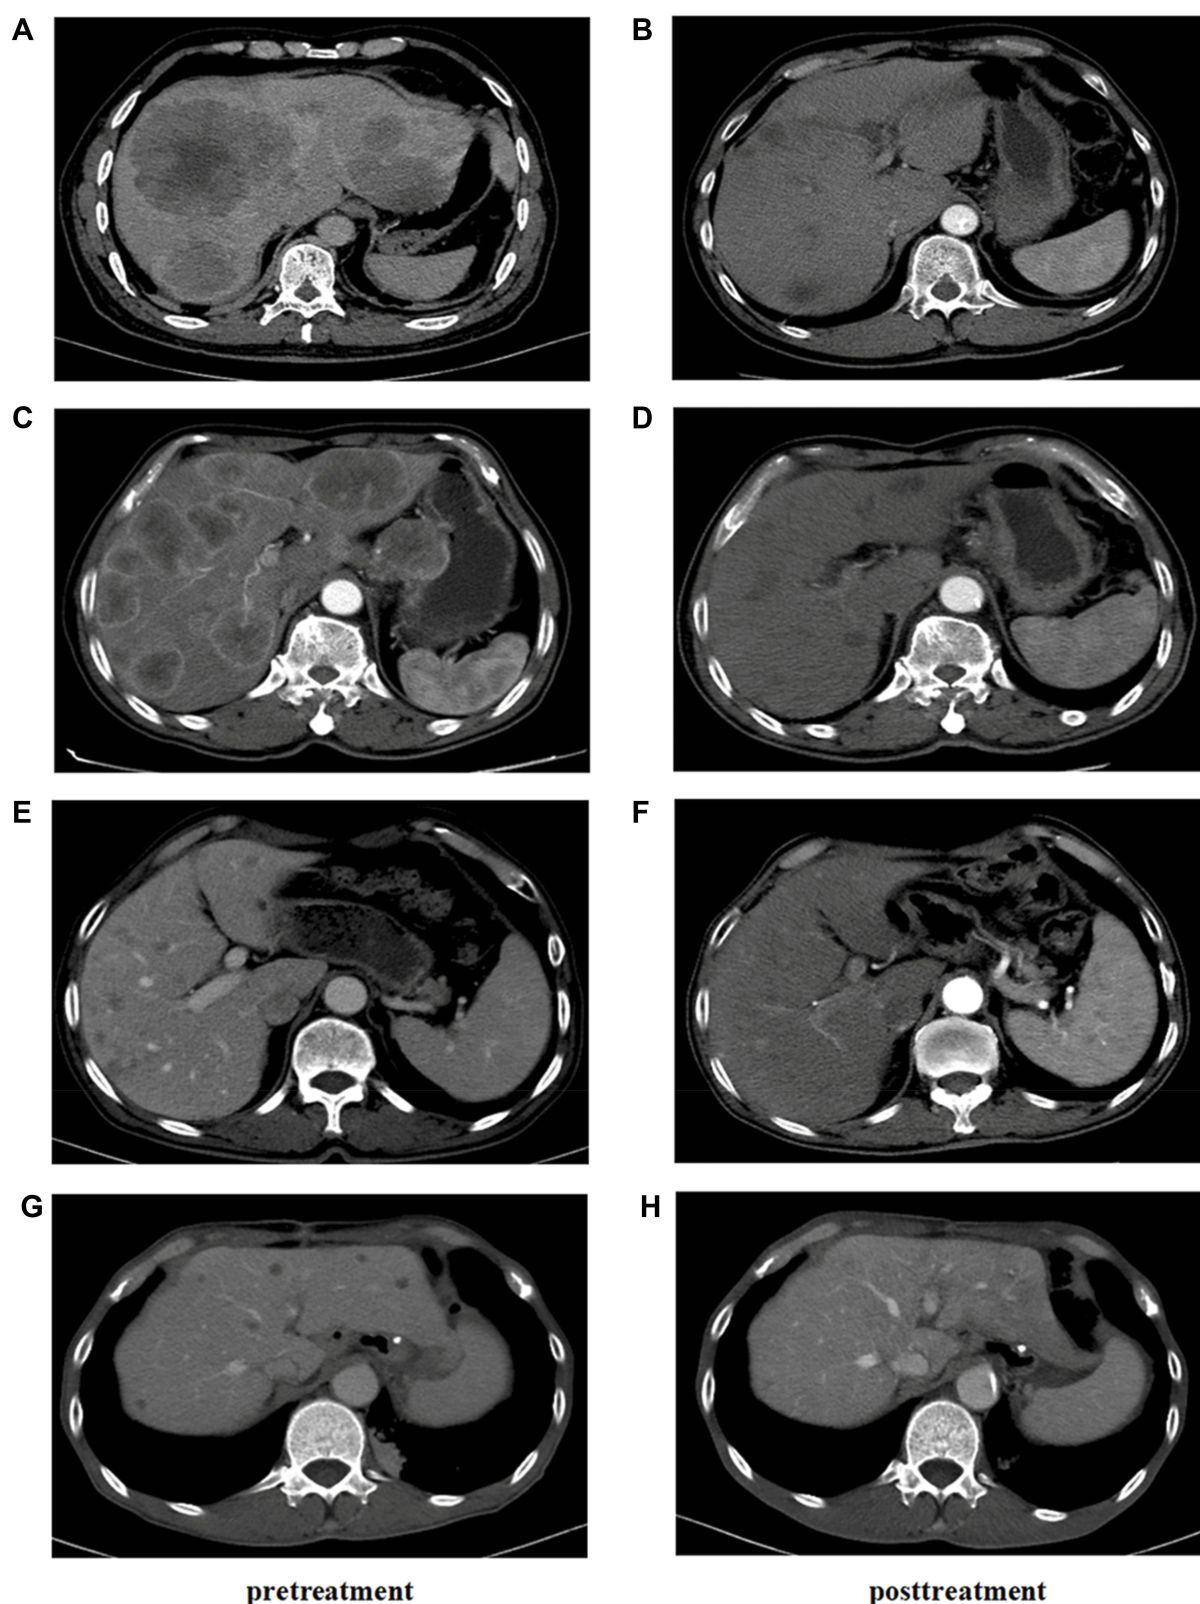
Follow-up CT scans after two cycles of HAI and systemic chemotherapy for each patient except No. 3 whose data were unavailable. (A, B) Patient No. 1, 58-year-old male showing marked liver metastases in CT images before therapy (A) and a significant shrinkage of the lesion after therapy (B). (C, D) Patient No. 2, 66-year-old male with unresectable liver metastases from gastric cancer (C) showing a decrease in the size and number of metastases after combined therapy (D). (E, F) Patient No. 4, 65-year-old male with multiple liver metastases after the failure of adjuvant therapy (E), showing the obvious response of lesions at 2 months after therapy (F). (G, H) Patient No. 5, 53-year-old male with multiple liver metastases after primary tumour resection (G) with a high-response rate in HAI, whose liver metastases disappeared gradually during treatment (H).
